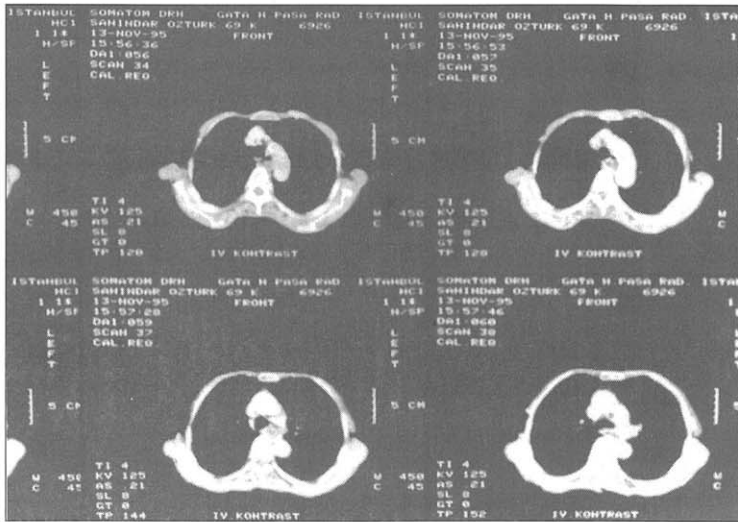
The appearance of esophageal lymphangioma in Computed Tomography
